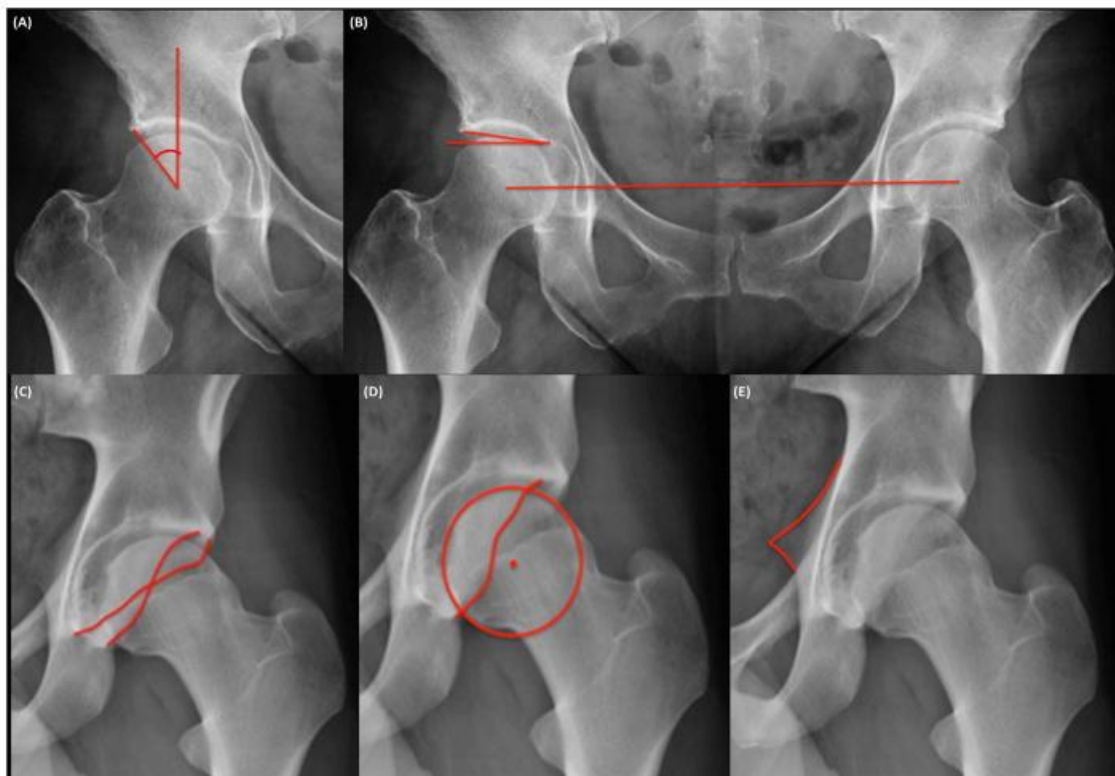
Apical acetabular measurements Cropped pelvic radiographs The Lateral Center Edge Angle (LCEA) is the angle formed by a vertical line to the pelvis and another line, extending to the lateral extent of the acetabular roof, with its vertex at the center of the femoral head. The Tönnis angle is formed by a horizontal line connecting the two femoral heads and a line connecting the medial and lateral extents of the acetabular roof. The crossover sign is characterized by the anterior wall extending laterally to the posterior wall before merging at the lateral acetabulum. The posterior wall sign is characterized by the posterior acetabular wall being positioned medially to the center of the femoral head. The ischial spine sign is recognized by the visibility of the ischial spine within the pelvic inlet on the anterior pelvis.
